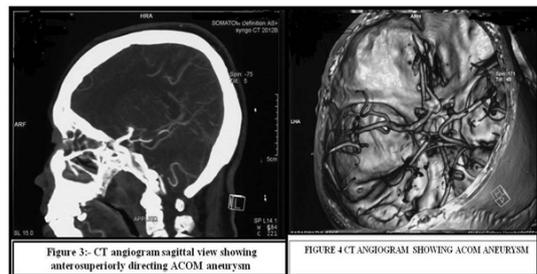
CT angiogram sagittal view showing anteroposteriorly directing ACOM aneurysm
